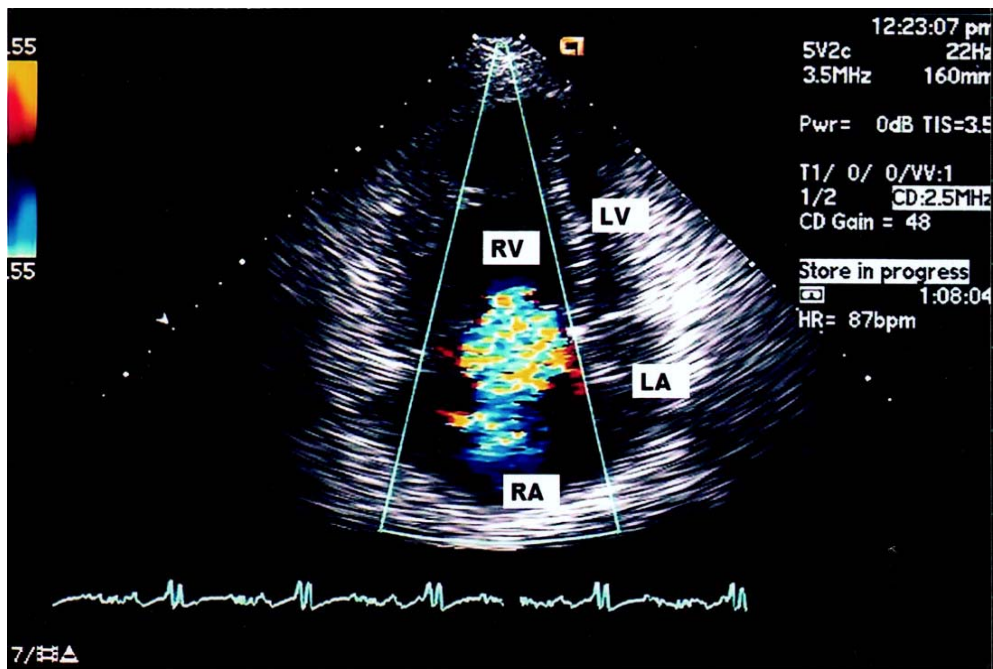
DOPPLER ECHO SHOWING REGURGITANT JET WITH DILATED RA AND RV
